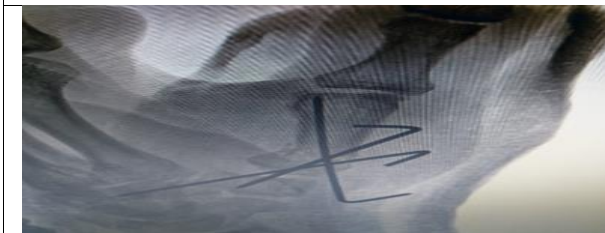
x-ray after surgery
